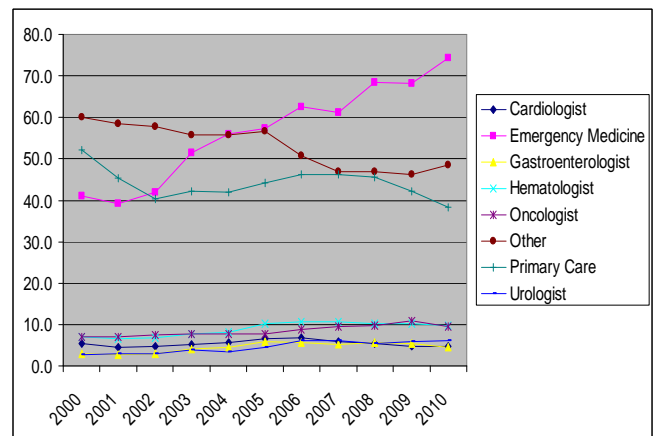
Utilization rates per 1,000 Paneled Primary Care patients for all CT imaging by ordering physician specialty from 2000 through 2010.
